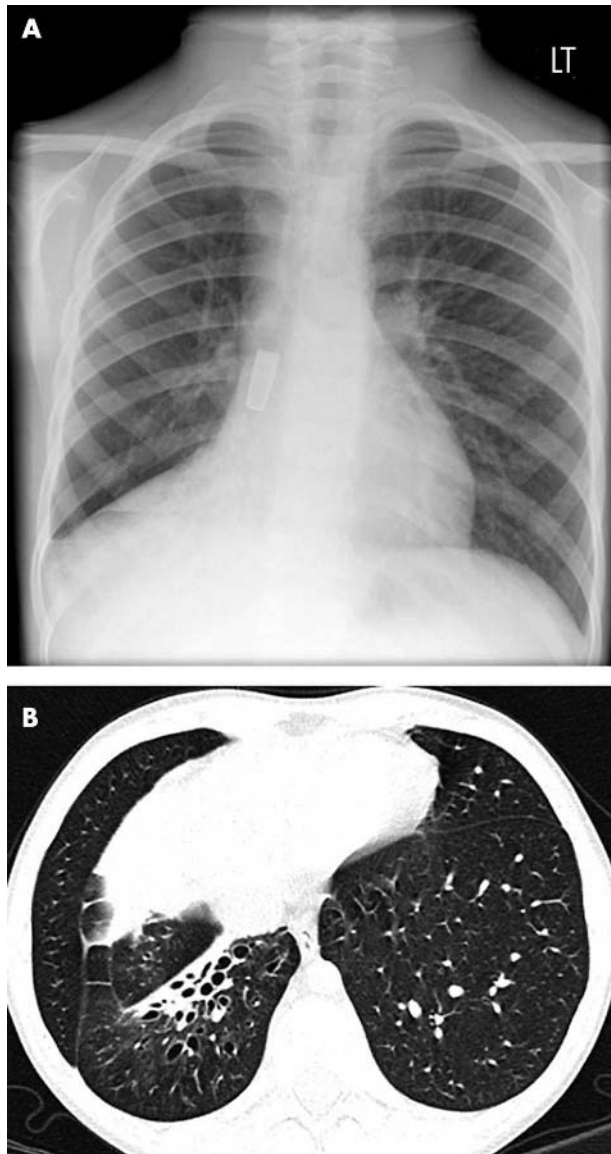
Case 3: chest radiograph and high resolution computed tomography scan.
